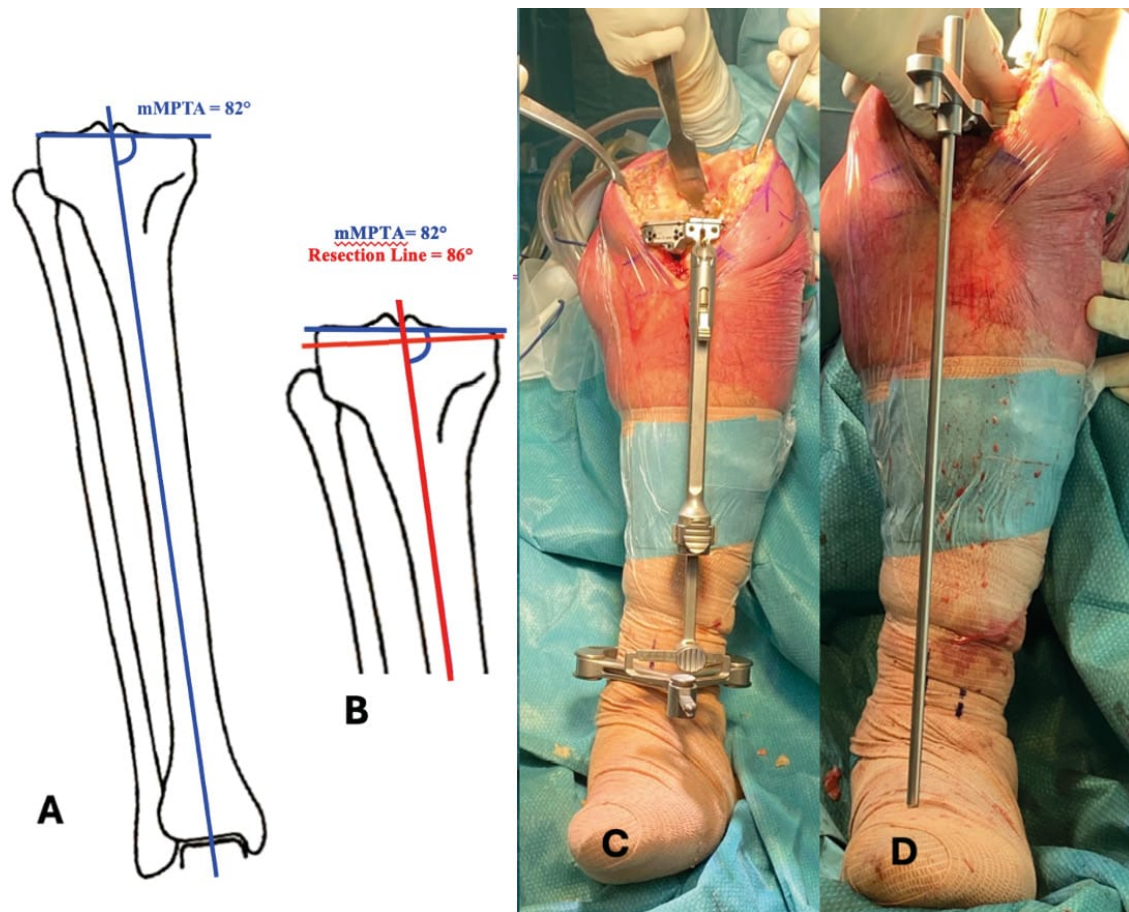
Example of achieving a personalized tibial cut during knee replacement surgery. - A. Preoperative mechanical medial proximal tibial angle (mMPTA) can be calculated on plain radiographs using digital software. - B. The preferred tibial cut is planned preoperatively according to the chosen alignment philosophy. - C. In this example, the extramedullary guide was lateralized to achieve the desired varus cut. - D. Fine incremental adjustments using a varus wedge positioned on the previously cut tibial plateau allow for the final verification that the preferred tibial varus cut angle has been accomplished.
